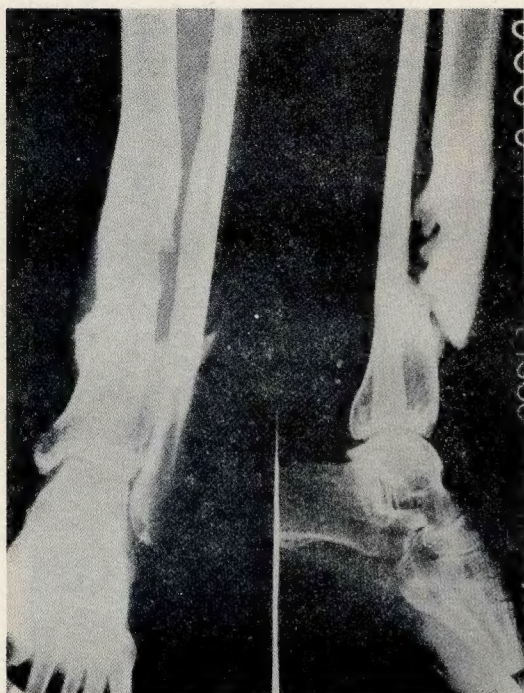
Case 3. Roentgenogram showing non-union of fracture of lower third of left tibia due to infection and inadequate immobilization.
